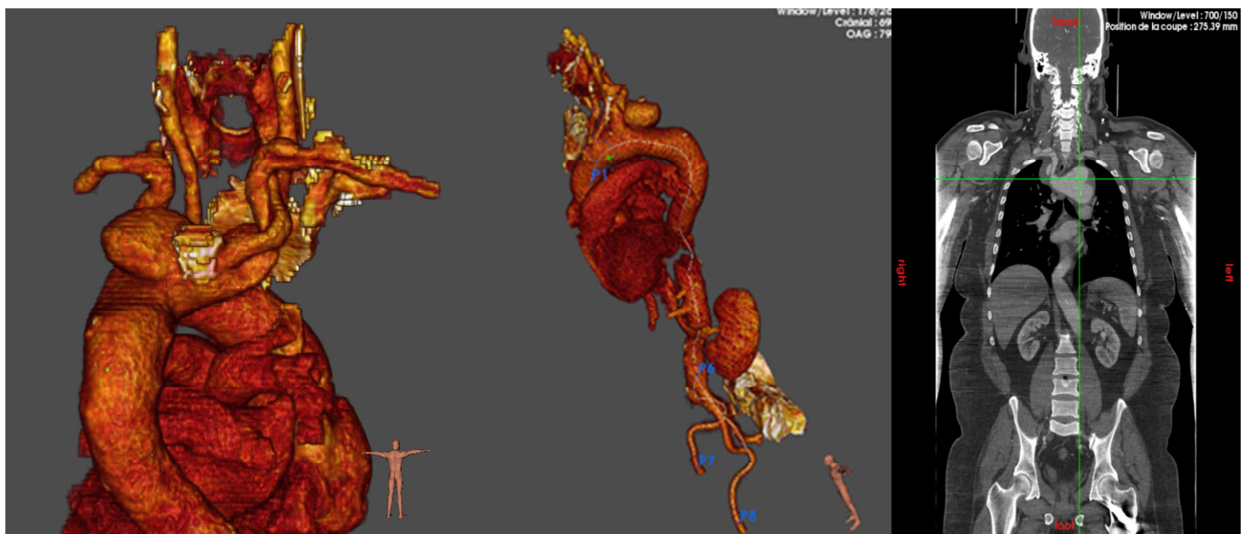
CT Scan of control, at 02 years, good evolution, at 02 years: thrombosis of the false lumen.
